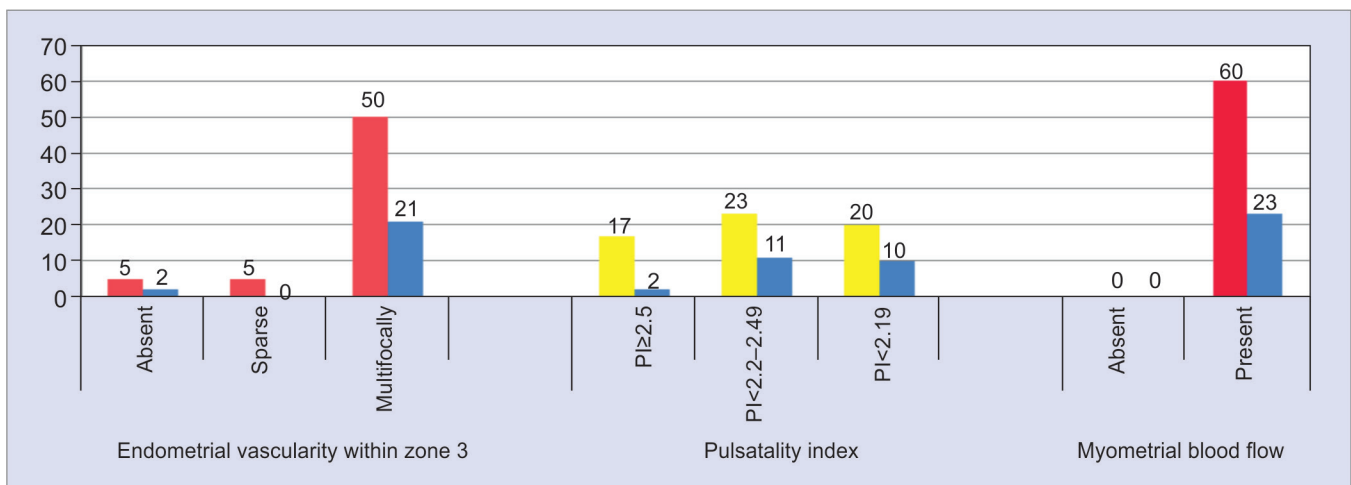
Correlation of Doppler parameters with pregnancy rate
